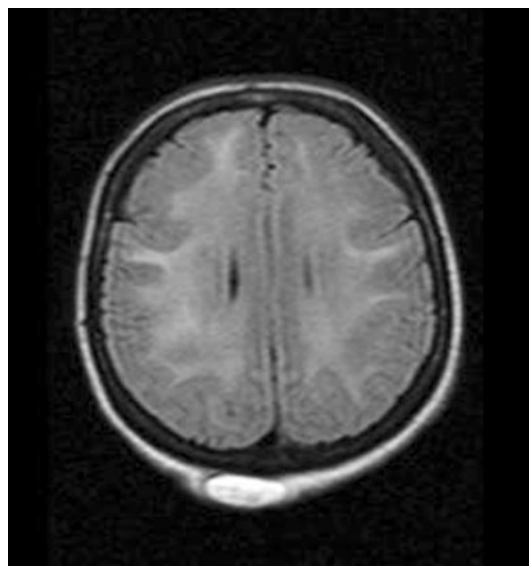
Cranial MRI with white-matter lesion on T2-weighted image (section3)
